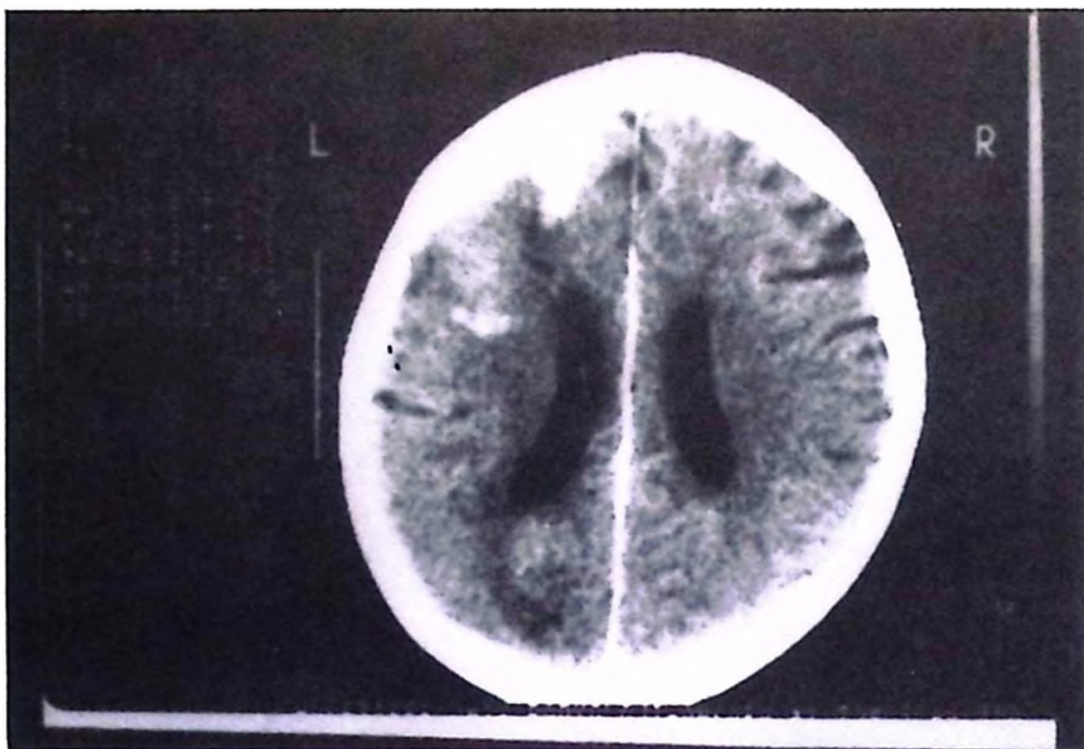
c: CT of Case 2: Hemorrhagic infarct in the left frontal lobe.
